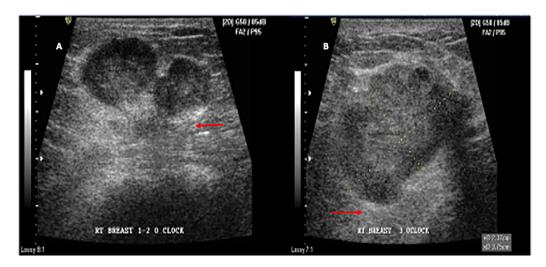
(Patient no. 1): Ultrasound of right breast 1-2 o'clock (A) and 3 o'clock (B) shows multiple solid, hypoechoic, sharply defined round to elliptical masses, few with gentle lobulations, which are in antiparallel orientation. The margins show a thin but well defined echogenic rim (red arrows). There is mild posterior enhancement in all the masses but no calcification is seen.
